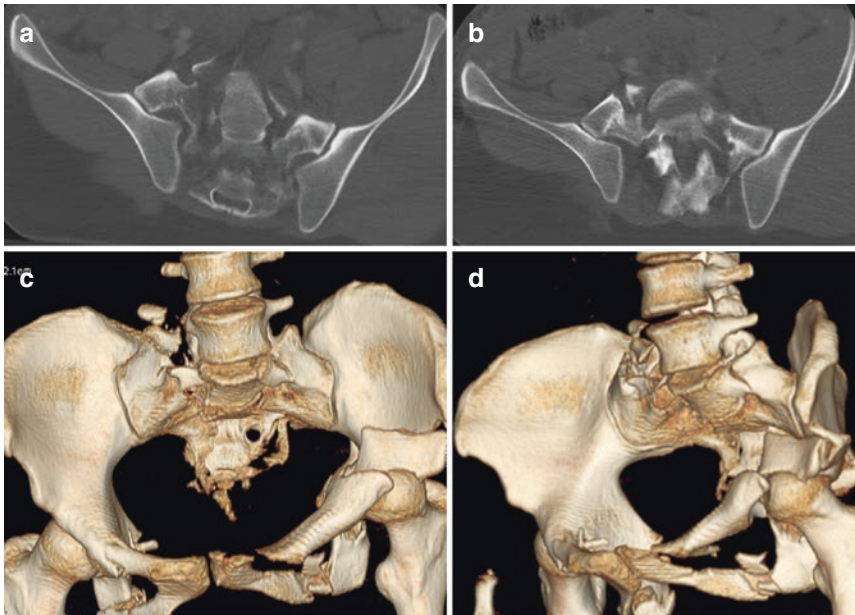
(a–d) Precipitated patient. “Vertical shear” (VS) fracture; condition of high instability. (a, b) CT axial view shows bilateral fractures of the sacrum along the course of the foramina, with diastasis of the sacroiliac
